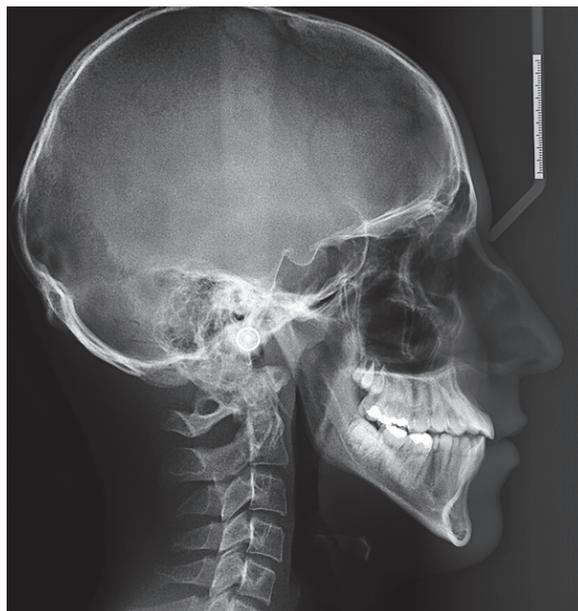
Post-treatment lateral cephalometric radiograph and cephalometric tracings.
